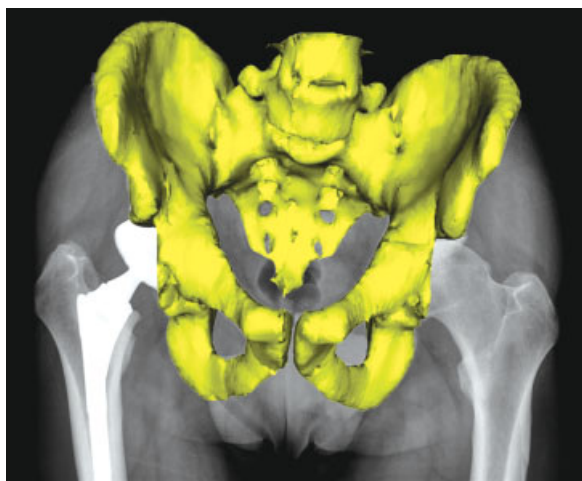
To measure cup orientation corrected for individual pelvic orientation, the software matches the 3D pelvic model from the preoperative CT with the contours of the postoperative radiograph. For visual verification, the software shows the result of the matching procedure.
